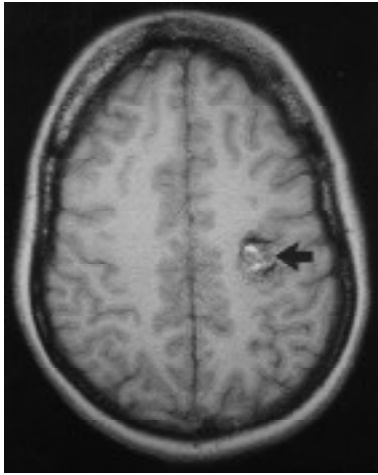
Patient with CVM. Axial fast spin echo T1-weighted MR image shows high signal intensity methaemoglobin within the lesion and a heterogeneous "mulberry" appearance (arrow).
